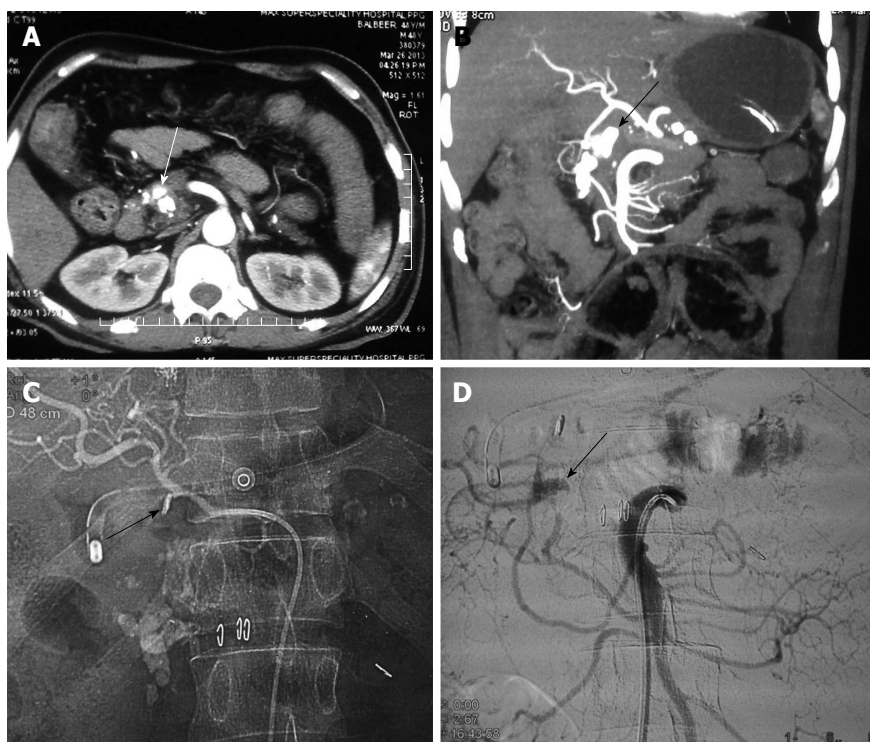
Chronic calcific pancreatitis with pseudoaneurysm of gastroduodenal artery (case 1). A: Axial Contrast enhanced; B: Coronal MIP (3-D reformatted) CT images; C: Angiographic spot image; D: Superior mesenteric DSA image. There is a pseudoaneurysm (arrow, A and B) arising from the gastroduodenal artery, which is filling from pancreatic arcade (Inferior pancreatic branches from SMA, D), because of metallic clip placed surgically at the origin of gastroduodenal artery origin (arrow, C). CT: Computed tomography; MIP: Maximum intensity projection; DSA: Digital subtraction angiography; SMA: Superior mesenteric artery.
